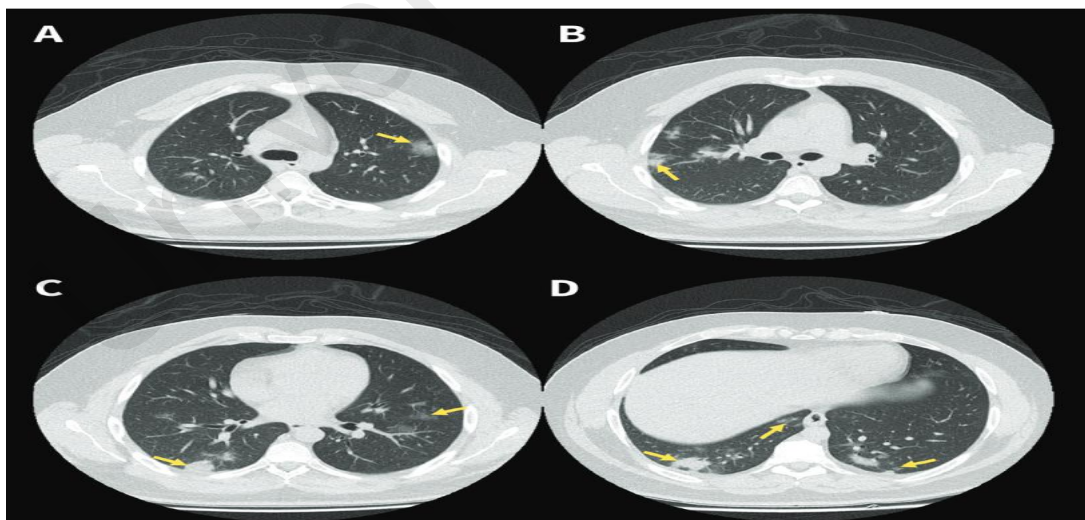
3 Chest CT Images of a 28-year-old Man Infected with Covid-19. it shows the typical lung characteristics of patients with new coronary pneumonia. A and B indicate that increased ground glass density, C and D lesions increase, and lower lobe is round.
